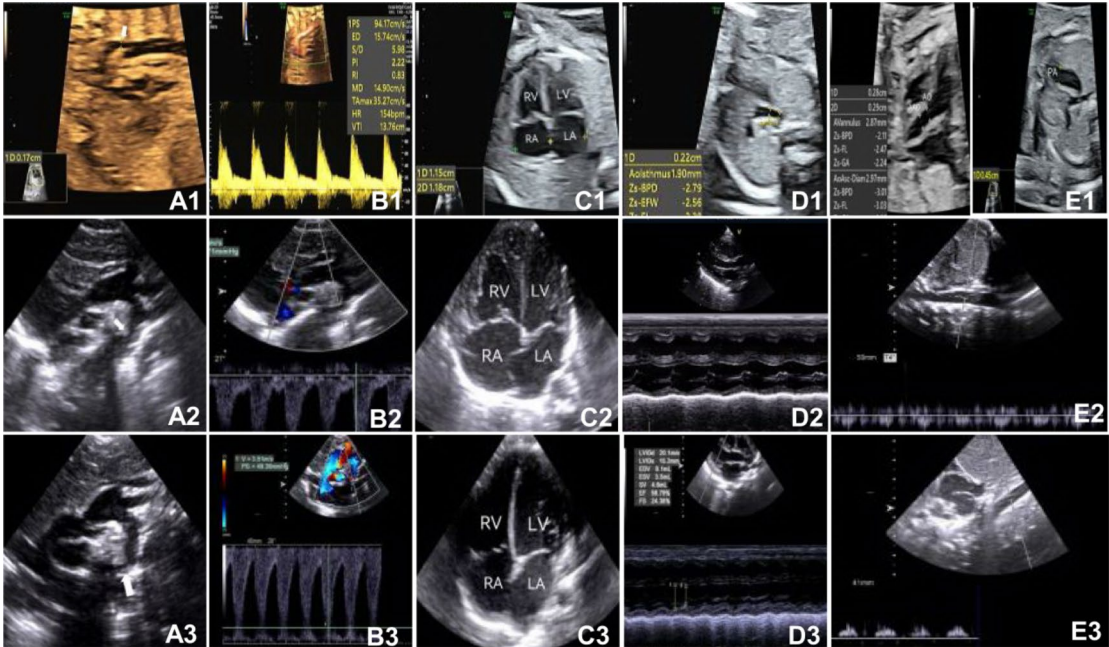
A baby with true coarctation of the aorta (CoA) before and after birth. (A1–E1) Fetal ultrasound image at the gestational age 24 weeks and 6 days after birth. (A1) In the aortic arch long axis section, a “stent sign” was shown in the aortic isthmus whose inner diameter was 0.17 cm (Z-Score: -3.65). (B1) The isthmic blood flow spectrum was normal with no obvious reflux. (C1) The left and right heart ratio was normal with the left atrial transverse diameter of 1.15 cm and right atrial transverse diameter of 1.18 cm. (D1) In the three vessel tracheal section, the isthmic inner diameter was 0.19 cm, and the aortic transverse arch inner diameter was 0.22 cm. (E1) The ratio of the pulmonary valve annulus diameter to the aortic valve annulus diameter was increased, and the aortic valve diameter was 0.28 cm (left) and the pulmonary artery was 0.45 cm (right). (A2–E2) Ultrasound images 35 h after birth before the closure of the ductus arteriosus (DA). (A2) The shape of the aortic arch is irregular, with a tortuous and thin inner diameter of 0.22 cm near the descending aorta at the distal end of the arch (→: thinner isthmus). (B2) The diastolic blood flow spectrum at this location increased with a peak systolic velocity (PSV) of 1.56 m/s at the isthmus and a pressure difference of 9.71 mmHg. (C2) The right heart is slightly larger. (D2) The left ventricular systolic function is normal with an ejection fraction (EF) of 63.02% and fraction of shortening (FS) 31.15%. (E2) The abdominal aortic spectrum showed a “small slow wave”. (A3–E3) Ultrasound images forty-two days after birth with closure of the DA. (A3) The distal end of the descending part of the aortic arch was thin, with an inner diameter of 0.23 cm (→: thinner isthmus). (B3) The flow velocity was significantly increased with a PSV 3.51 m/s and a pressure difference of 49.36mmHg. (C3) The left ventricle was slightly larger in the four chamber view. (D3) The left ventricular systolic function was reduced with an EF 56.79% and FS 24.38%. (E3) The abdominal aortic spectrum was a “small slow wave”. LA left atrium, LV left ventricle, RA right atrium, RV right ventricle, AO aorta, AA0 ascending aorta, and PA pulmonary artery.
